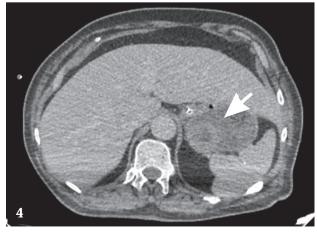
CTA: Axial image in the portal venous phase demonstrates an almost spherical mass, with peripheral enhancement and a hypodense center, attributed to central necrosis (arrow), as is typically the case with GISTs.
